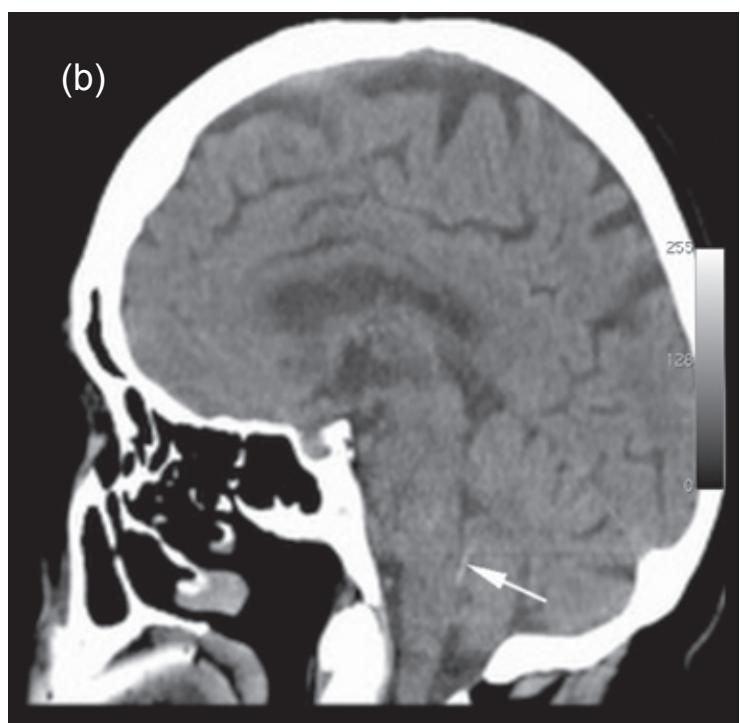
Unenhanced CT brain sagittal image demonstrating hyper densities within the fourth ventricle (arrows).
